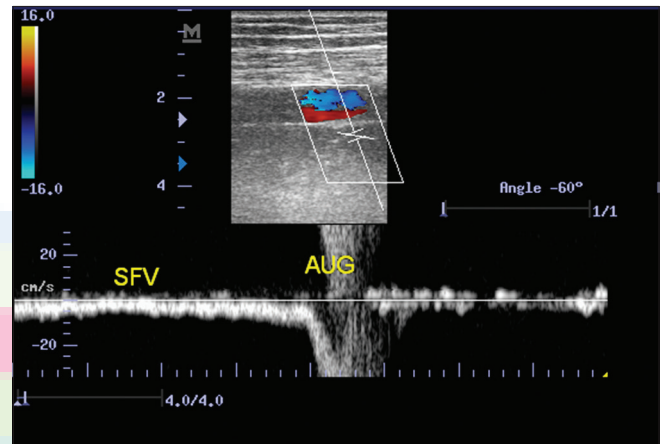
A spectral Doppler sonogram of the superficial femoral vein in a patient with ilio-femoral partial thrombosis. Note the positive augmentation response but without respiratory variation
